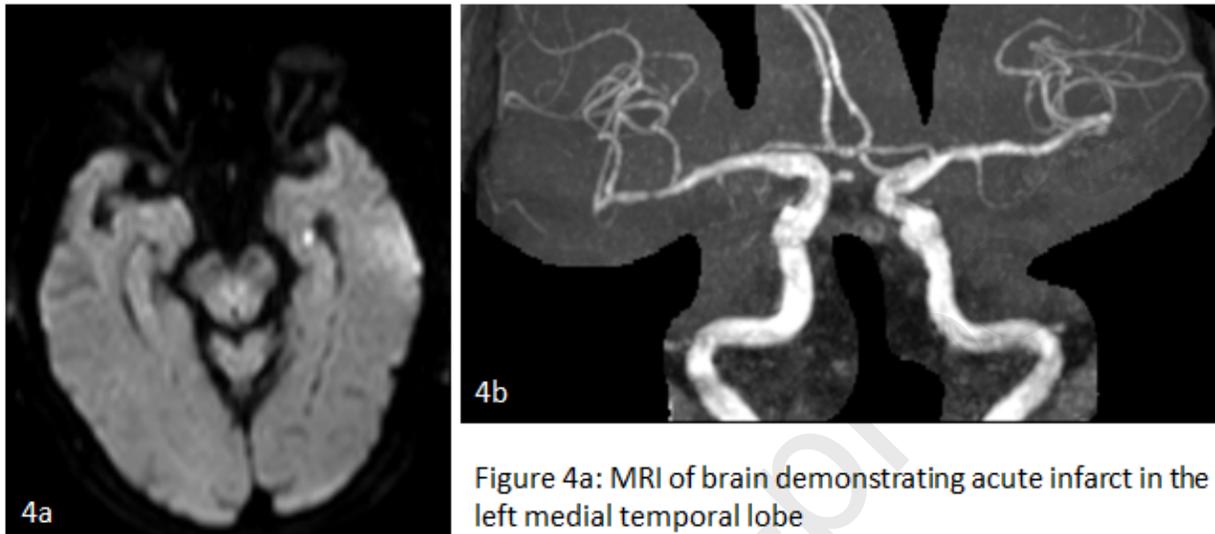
MRI of brain demonstrating acute infarct in the left medial temporal lobe
